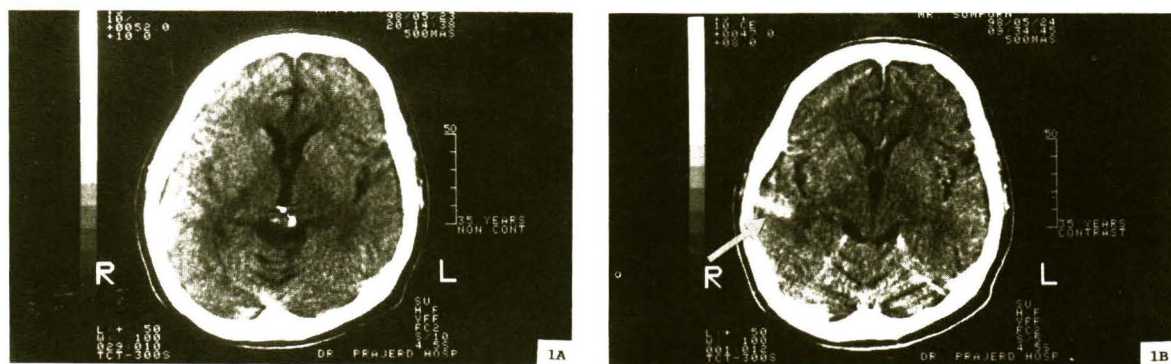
Pre- (A) and post- contrast (B) axial CT scans showed a gyriform enhancement in the right temporal lobe with minimal surrounding oedema. An identical change with a lesser severity in the left temporal cortex was also noted.
